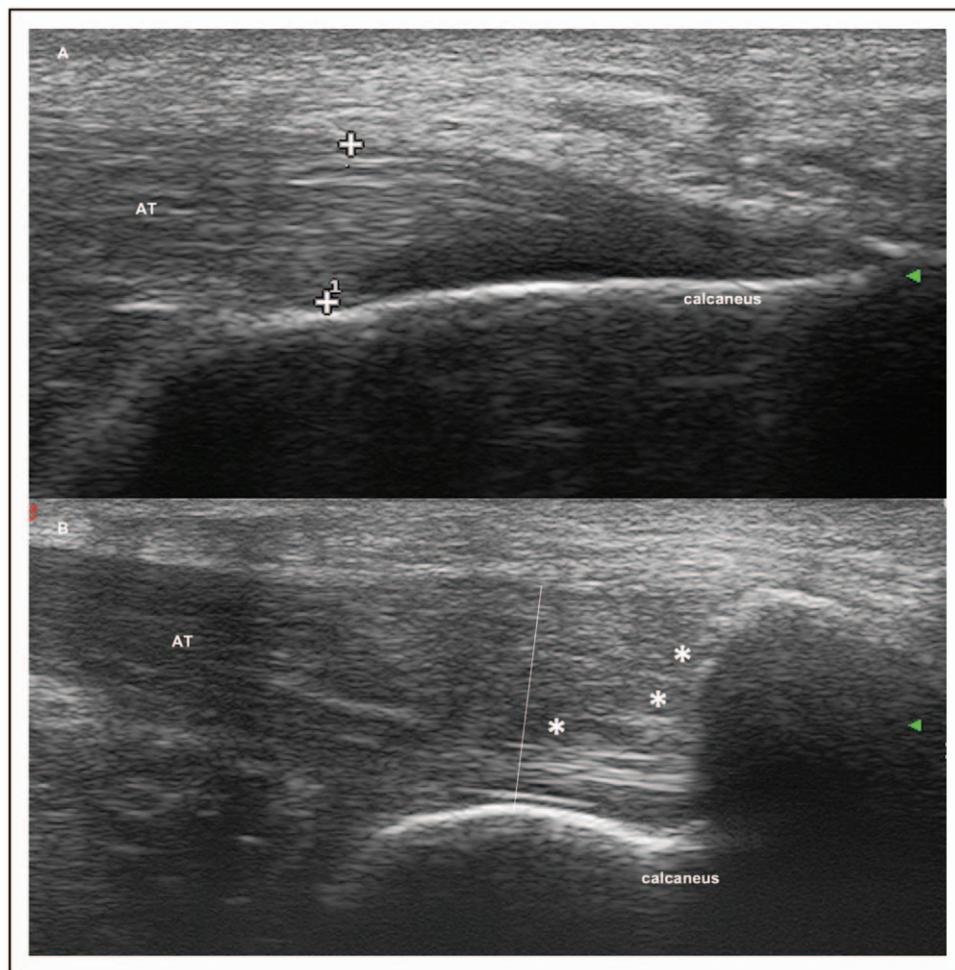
Enthesal thickening on longitudinal scans of the Achilles enthesis on ultrasound. The upper limit for the Achilles enthesis thickness is 5.29 mms. (a) Thickening of the Achilles enthesis with normal fibrillary echotexture (distance between the + signs; thickness 5.8 mm); (b) Thickening (line) because of infiltrates (*) separating the enthesal fibers. AT, Achilles tendon.
